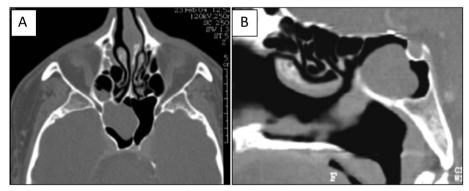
Case 4. Spheno-choanal polyp. CT scan axial view (A left) showing a right sphenoid sinus mass with posterior ethmoidal cell's retention. Sagittal view (B right) showing a sphenoid sinus's well-defined mass expanded to the rhinopharynx suggesting a spheno-choanal polyp
